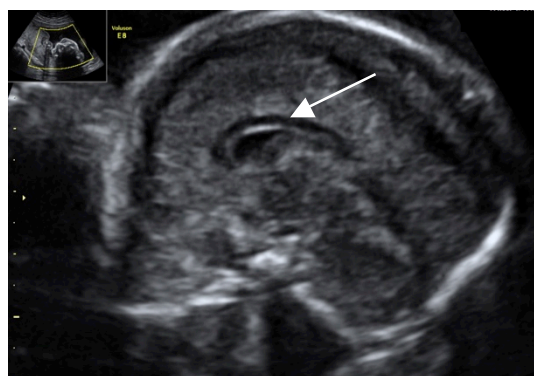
Visualisation of the CC on ultrasound during the 21st gestational week.
